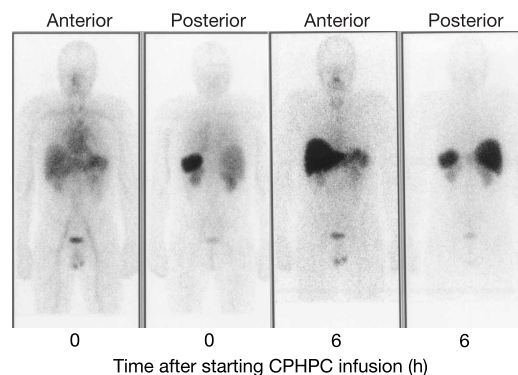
Whole-body ¹²³I-labelled SAP scintigraphy before and 6 h after starting infusion of CPHPC. The figure shows a patient with a modest load of AL amyloid in the spleen and kidneys, with notable blood pool background of tracer in the heart and circulation before administration of the drug (left panel). At 6 h the blood pool background is completely absent and the liver, which is the only site of catabolism of SAP *in vivo*, has taken up the tracer while the intensity of SAP signal from the amyloidotic spleen and kidneys is significantly reduced.
